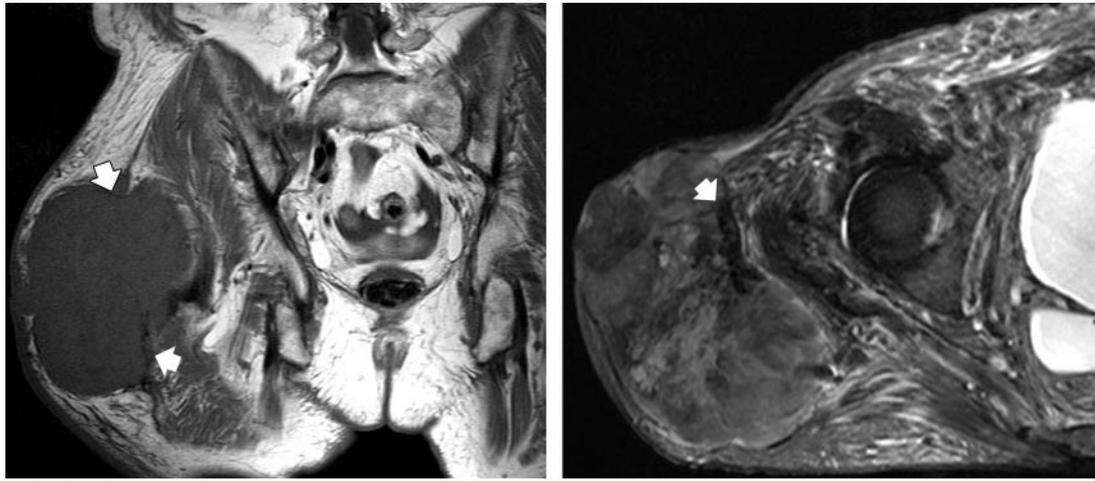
Superficial malignant fibrous histiocytoma in the upper thigh of a 78-year-old man. (a) Coronal T1-weighted (700/13) SE MR image shows a large hypointense mass (arrows) that has arisen in the subcutaneous tissue and has invaded and penetrated the tensor fascia lata. (b) Axial T2-weighted (2540/80) SE MR image shows heterogeneously hypointense signal in the mass, as well as abnormal thickening of the tensor fascia lata (arrow).
